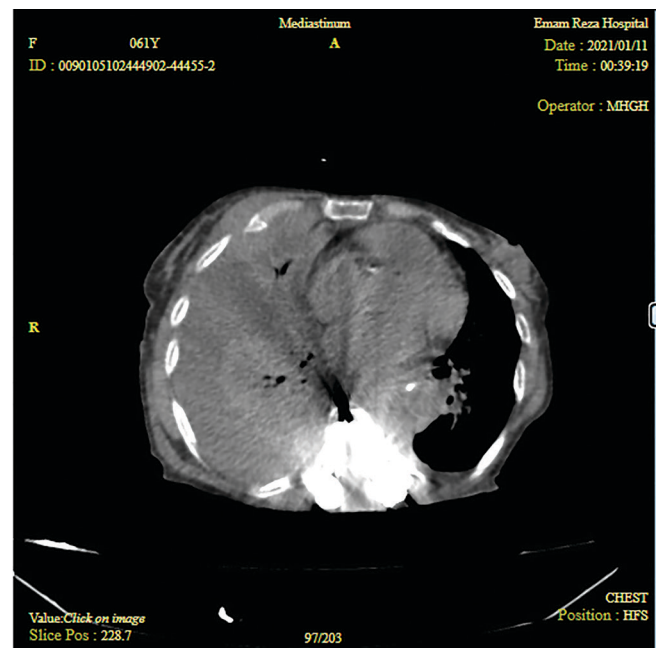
CT of the thorax showed unilateral sided pleural effusions in the right side.
